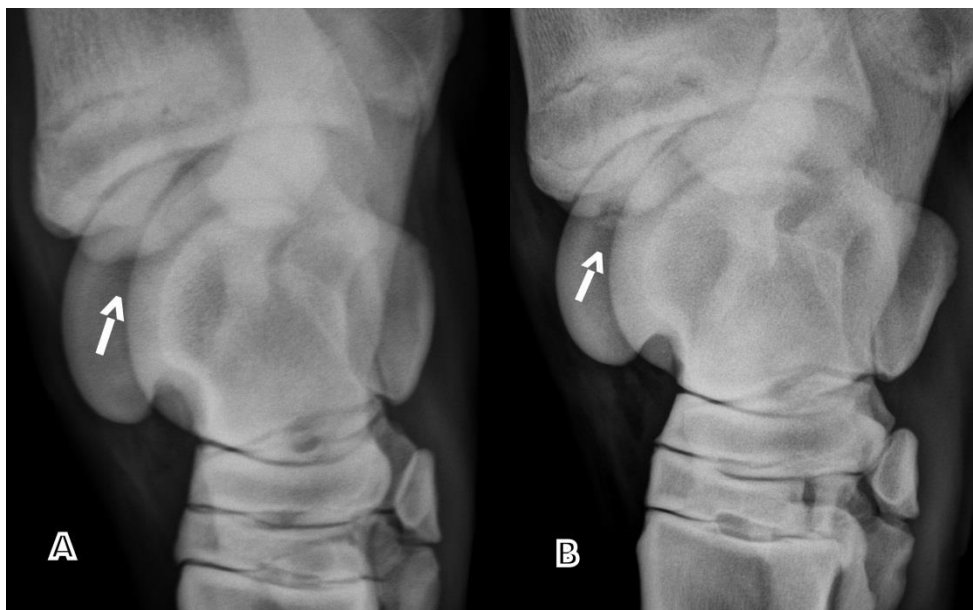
Dorsomedial-plantarolateral oblique radiographic view of tarsus showing changes (arrows) categorised as (A) concavity or (B) fragmentation of the intermediate ridge of the distal tibia.
